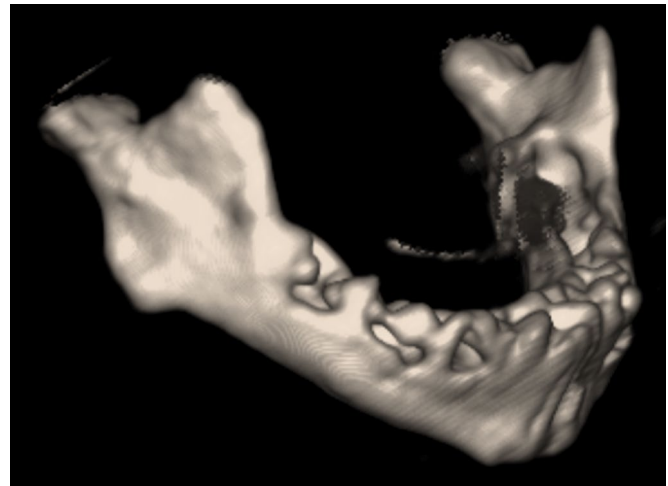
Three-dimensional computed tomography reconstruction of the neonatal mandible in an infant with micrognathia. Note the obtuse mandibular angle and relatively short mandibular ramus.
